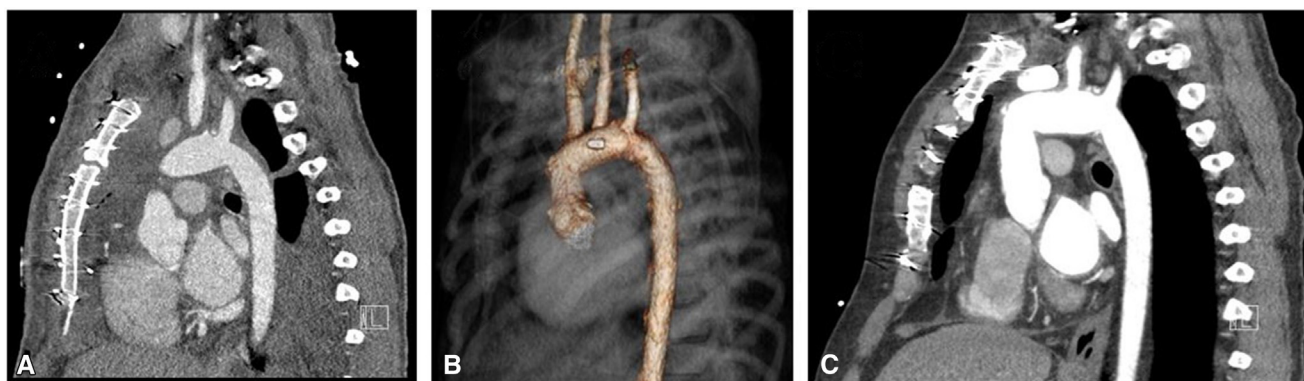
Follow-up computed tomography (CT) angiography on postoperative day 3 highlighting the repair (A) and its 3-dimensional reconstruction (B). Repeat CT angiography 4 years postoperatively highlighting the robust repair (C).
